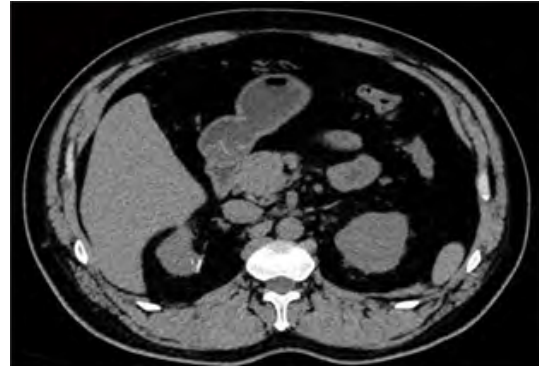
In the seventh month after surgery, the case 2 underwent a CT examination.
